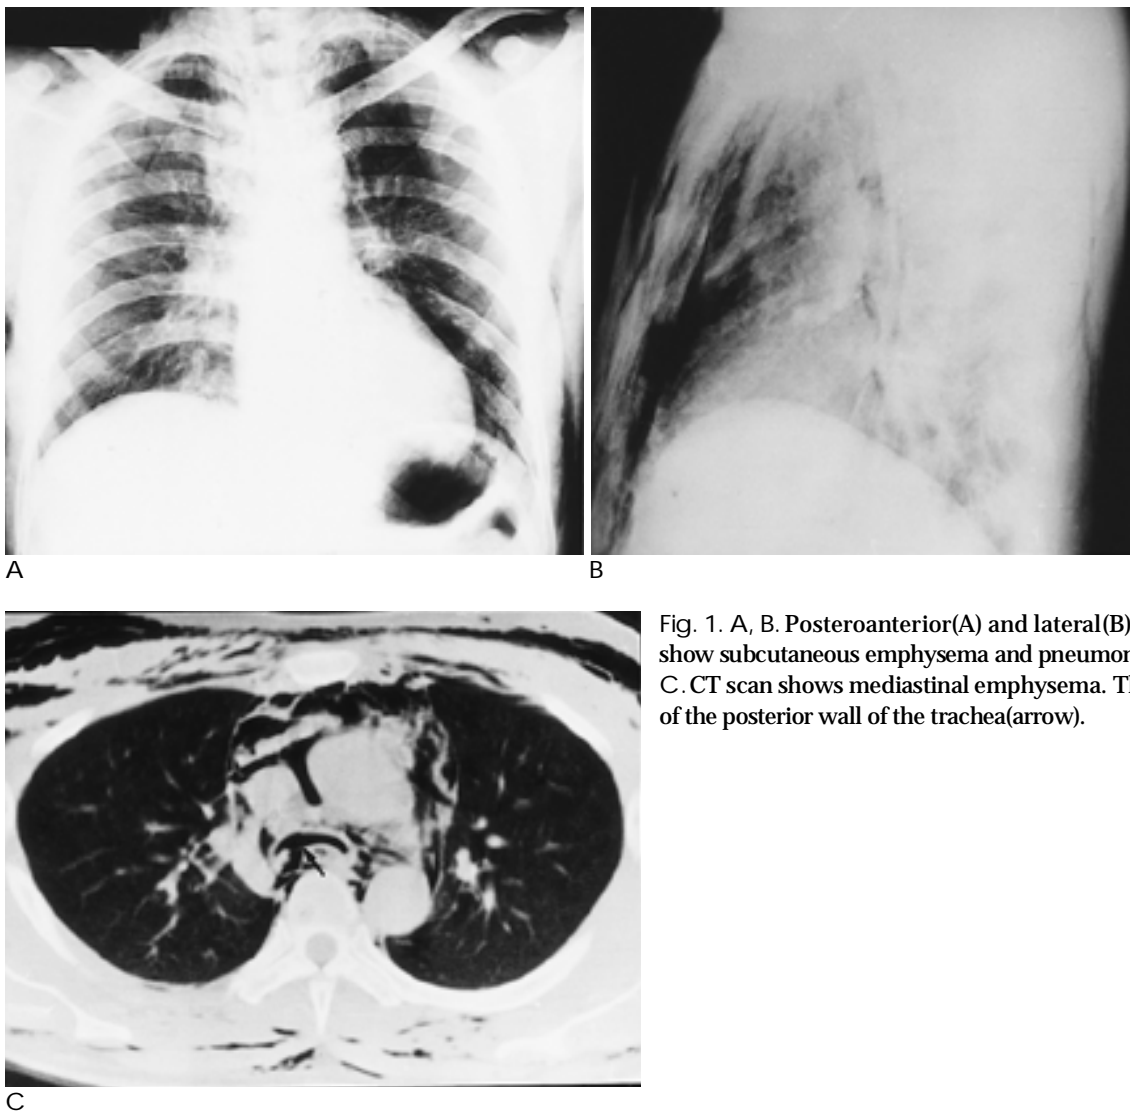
A, B. Posteroanterior(A) and lateral(B) chest radiographs show subcutaneous emphysema and pneumomediastinum. C. CT scan shows mediastinal emphysema. There is a disruption of the posterior wall of the trachea(arrow).
